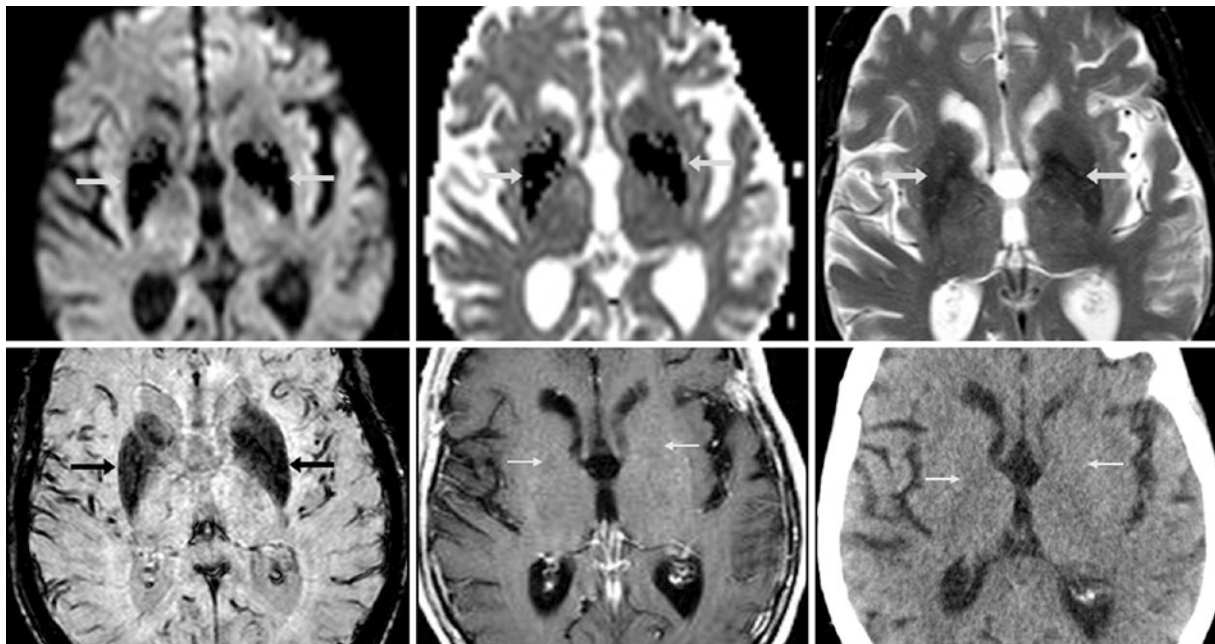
A 79-year-old with a 1.5 T MRI that shows T2 blackout (*arrows*) within the lentiform nuclei on DWI (*top left*), ADC map (*top middle*), T2WI (*top right*), and SWI (*bottom left*). T1WI (*bottom*
